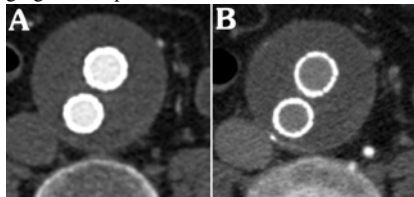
CT angiography image a) arterial phase, b) late phase (2 minutes after injection), images of same patient as Figure 2. No endoleak is visible.
